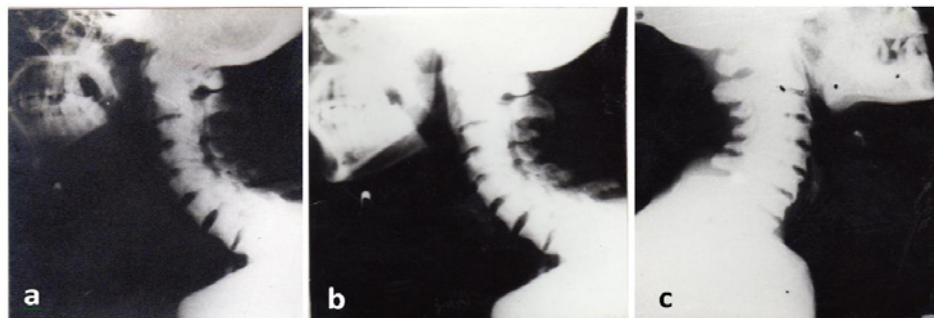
Radiographs of cervical spines of subjects having mild (a), moderate (b), and severe (c) skeletal fluorosis showing progressive osteosclerosis, osteophytosis, and calcification of thyroid cartilage.
